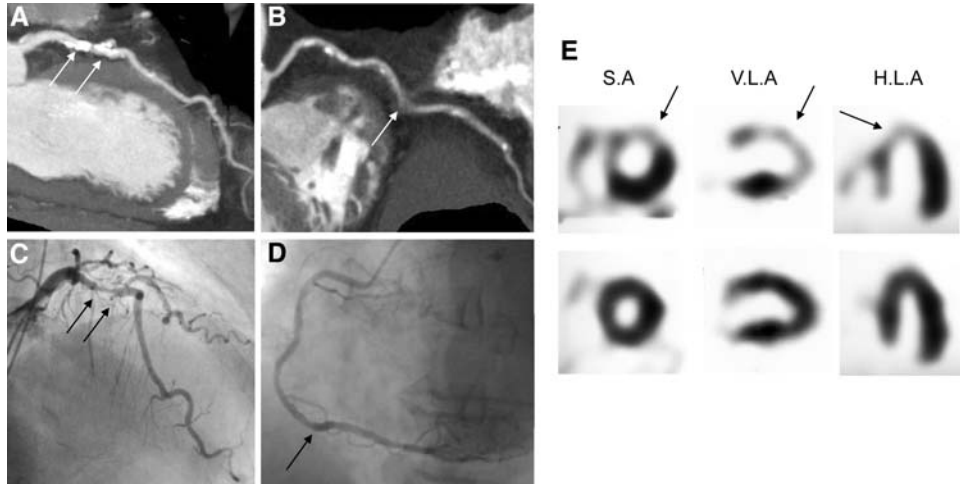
Results of a 68-year-old man with chest pain. A, Computed tomography angiography (CTA) reveals a severely calcified lesion (*arrows*) in the proximal LAD. B, CTA shows a poor image with motion artifact (*arrow*) in the mid RCA. C, Invasive coronary angiography (ICA) shows the presence of a significant stenosis in the proximal LAD. D, ICA shows no significant stenosis in the mid RCA. E, Corresponding nuclear myocardial perfusion imaging during stress (*top row*) and rest (*bottom row*) shows a reversible perfusion abnormality in the anterior, septal and apical walls (*arrows*). SA, Short axis; VLA, vertical long axis; HLA, horizontal long axis.
